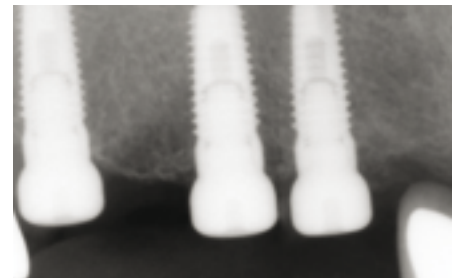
Postoperative radiologic exam: periapical radiograph.
